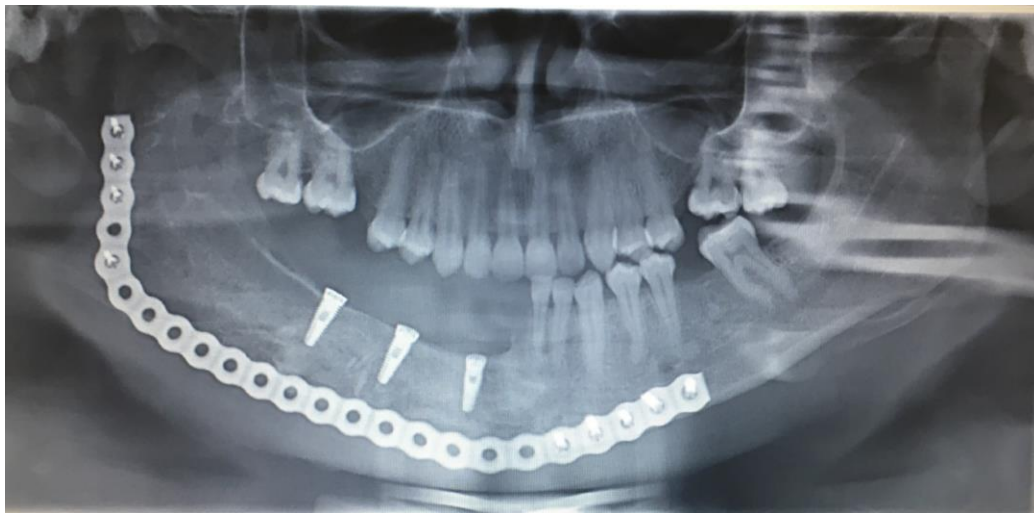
Panoramic radiograph following implant placement
